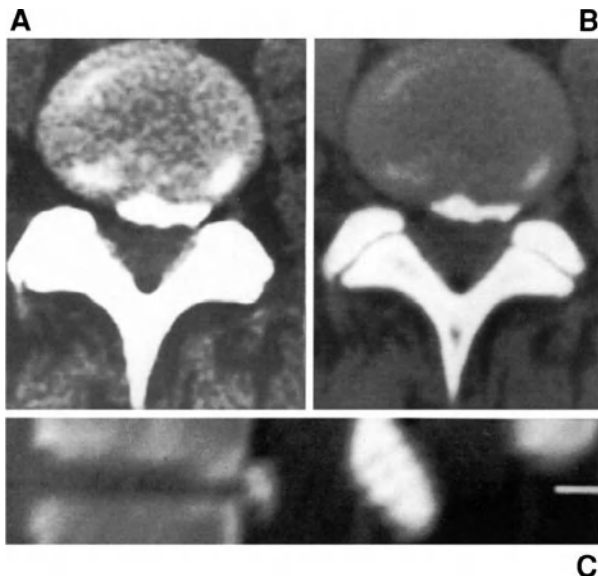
Calcification of the posterior annulus fibrosus. Axial CT images with a window level for soft tissues (A) and bone (B), and sagittal reconstruction with a window level for bone (C). Only from the reconstruction is it possible to determine that the hyperdense bar visible on axial images does not originate from the vertebral end-plate, but is an annular calcification.
